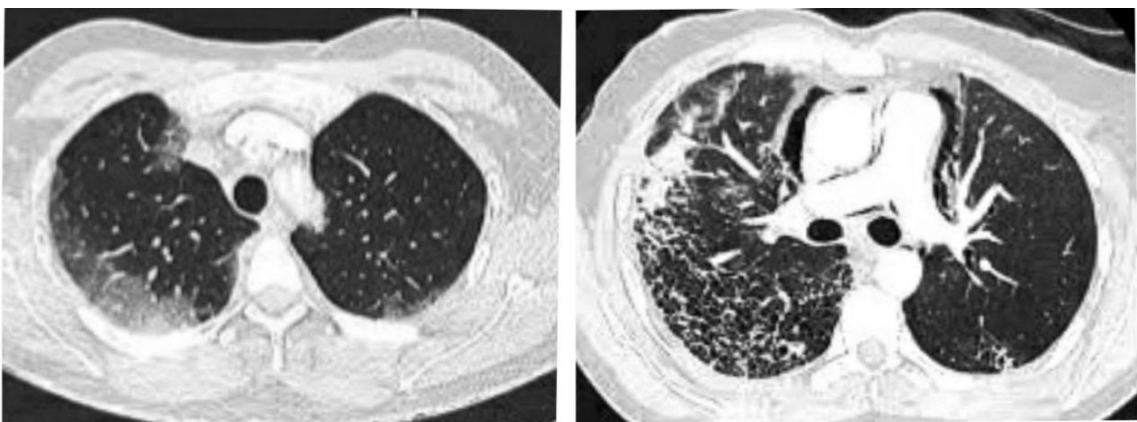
CT scan showing multiple patches of peripheral ground glass opacities seen majorly in posterior base of bilateral lungs with few areas of consolidation in the background of interlobular septal thickening.
